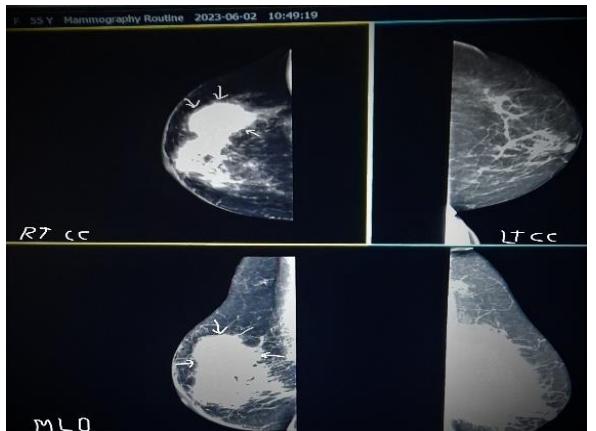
Digital Mammography -X-ray CC/MLO Views
